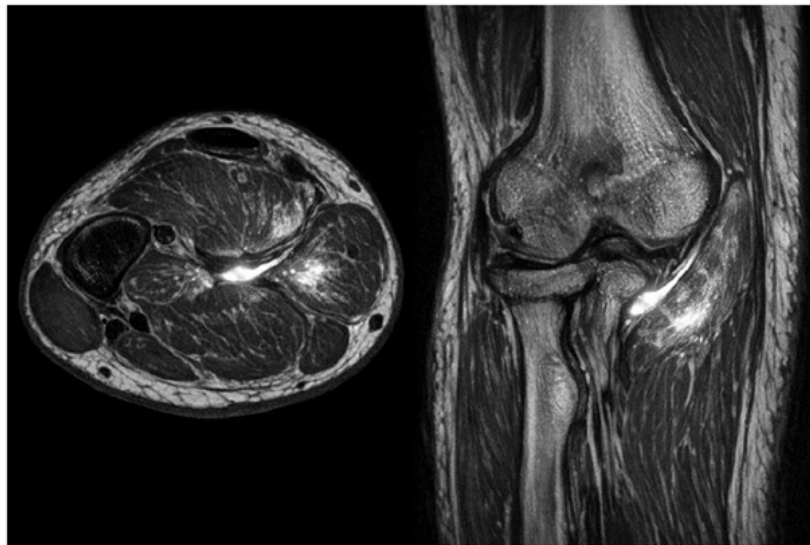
Integrated neuroimaging for PIN syndrome: 3T MRI neurography and high-resolution ultrasonography demonstrating nerve edema, denervation muscle signal changes, and focal nerve enlargement at the supinator entrance, providing superior lesion site localization (85-92% combined sensitivity) for surgical planning.
